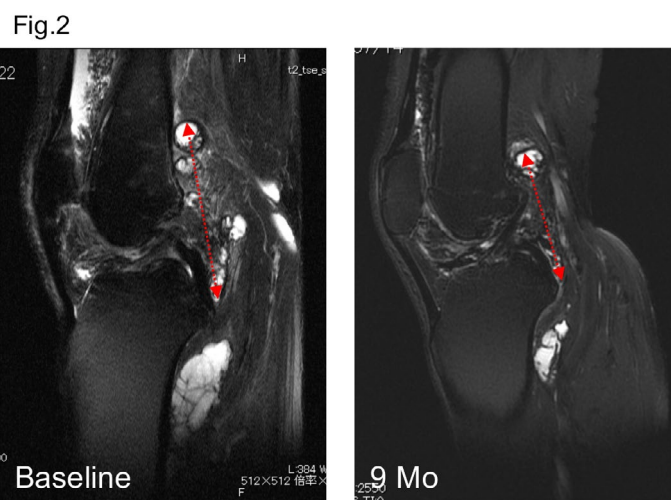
Case K5. The baseline MRI showed the large D-TGCT occurred in the suprapatellar pouch and the popliteal fossa. The longest diameter of the posterior lesion (dashed red line) decreased from 81.1mm to 76.1 (6.2%) at 9 months. Synovial fluid was also decreased.
